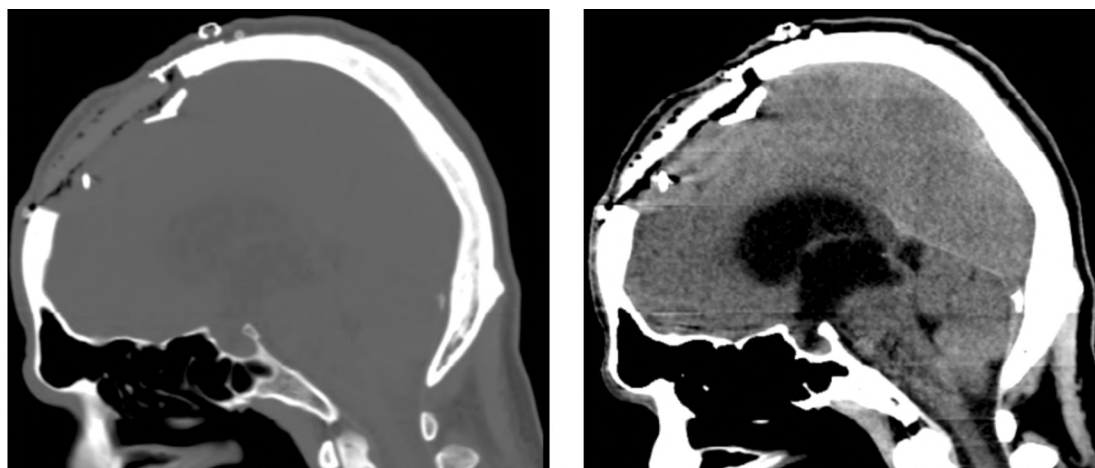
Post-operative sagittal CT brain reconstruction without contrast (Right: Soft window, left bone window) showing bifrontal craniectomy with insertion of synthetic mesh, after excision of both extradural and extra-cranial SOL with clipping of SSS.
